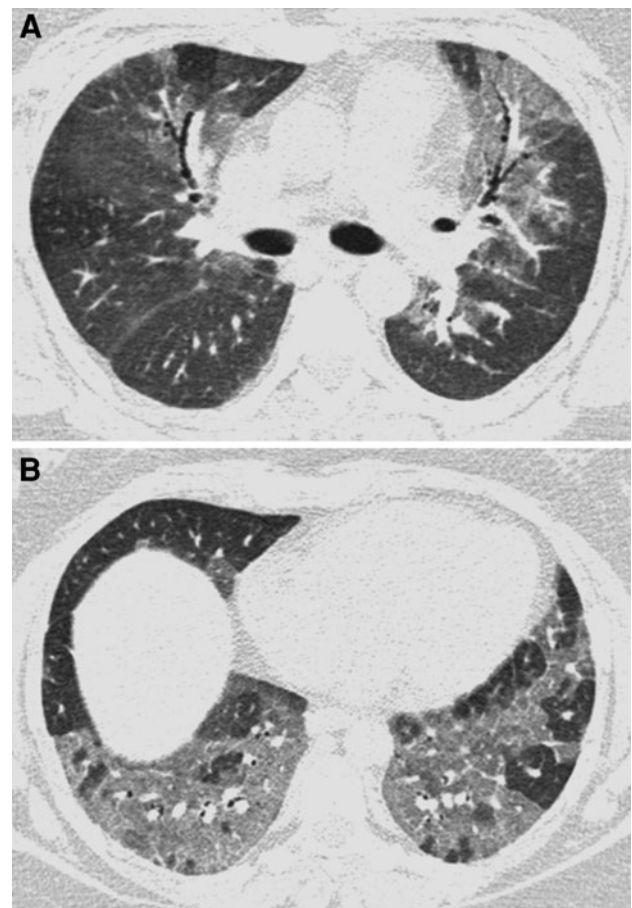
A 59-year-old man with dengue hemorrhagic fever and diffuse alveolar hemorrhage. High-resolution computed tomography at the levels of the carina (a) and lower lobes (b) shows extensive areas of ground-glass opacities in both lungs
